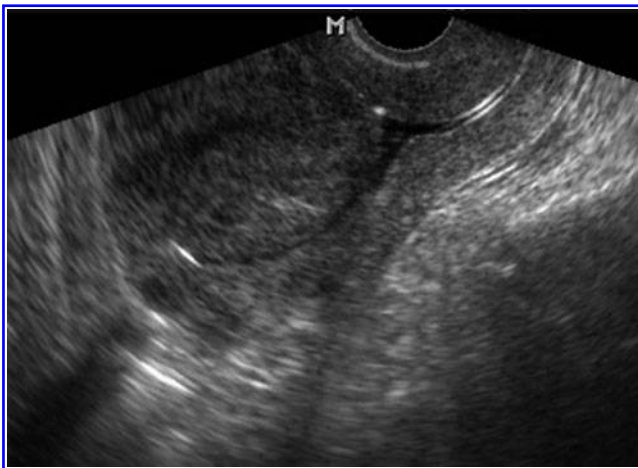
Transvaginal 2D ultrasound with saline infusion hysterosonogram picture showing an 8-cm large anterior-fundal submucous intramural fibroid reaching and stretching the serosal layer (type 2 submucous fibroid). Taken from ISBN: HB 9781107029743. Edited by Botros R.M.B. Rizk and Elizabeth Puscheck. Ultrasonography in Gynecology. Figure 15 in the book chapter "Transvaginal ultrasound scan findings of uterine fibroid effect on treatment plan." By Dr. Mostafa Abuzeid and Salem Joseph. Copyright © 2012 Cambridge University Press. Reprinted with the permission of Cambridge University Press.
